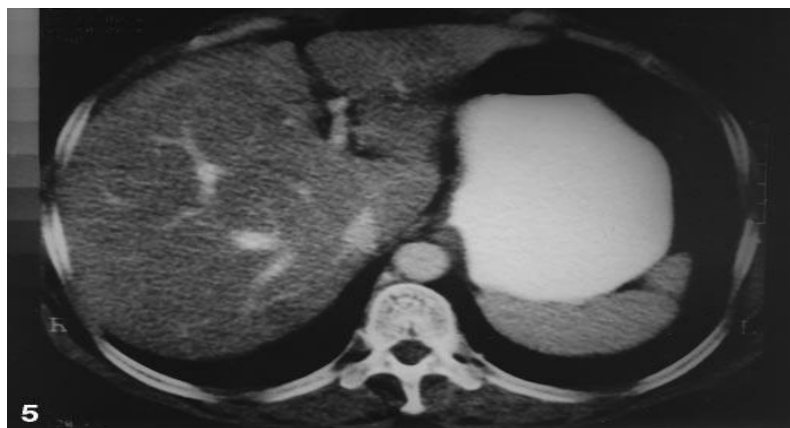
Continuation of CT scan one year afterwards percutaneous drainage is entirely regular.
